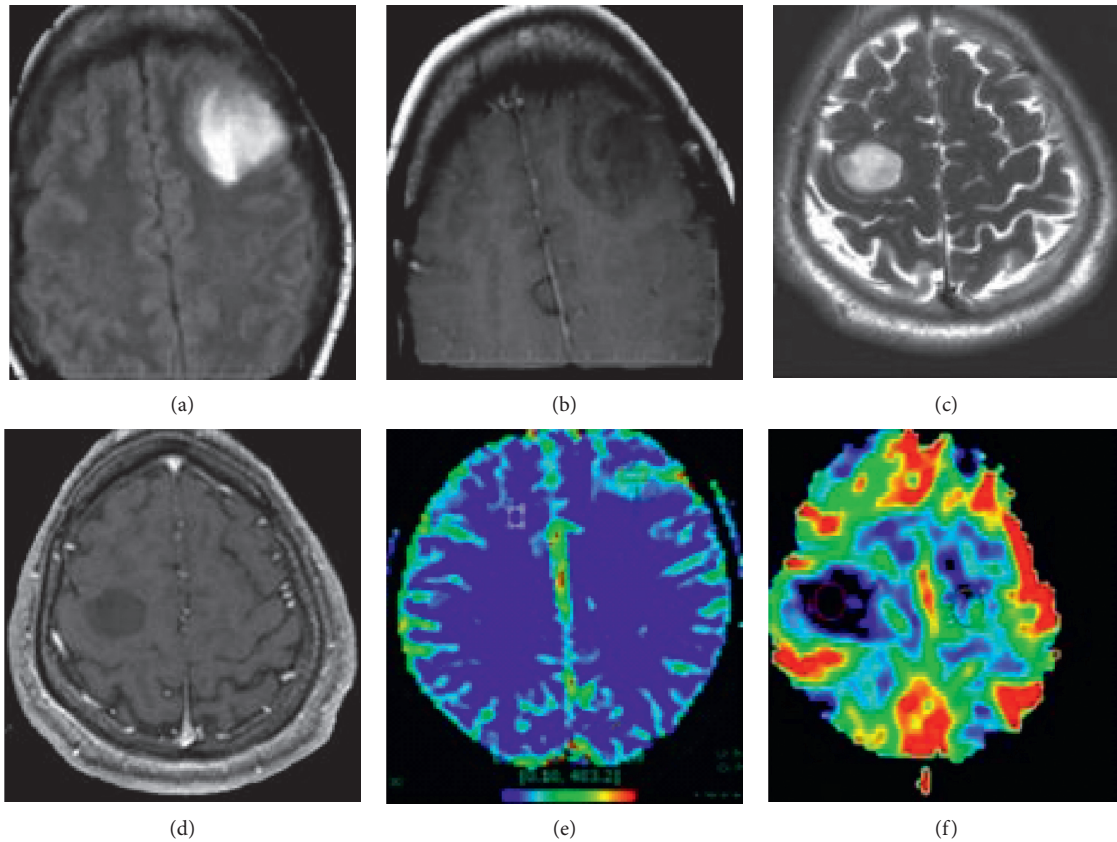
An MRI image of a male with BG. FLAIR sequence of patients with grade III anaplastic astrocytoma (a) indicated a hyperintensity focus in the left frontal lobe and a hypointensity for T1WI enhancement (b). There was no enhancement due to the integrity of the blood brain barrier. The CBV value on the left side of the rCBV was 5.7 times higher than that of the contralateral frontal lobe, indicating that the tumor tissue had a higher capillary density (c); in patients with grade II fibrous astrocytoma, a hyperintensity focus was observed in the right frontal lobe for T2WI (d). Similarly, there was no obvious enhancement for the focus (e), and there was no obvious increase in focal rCBV (f).
